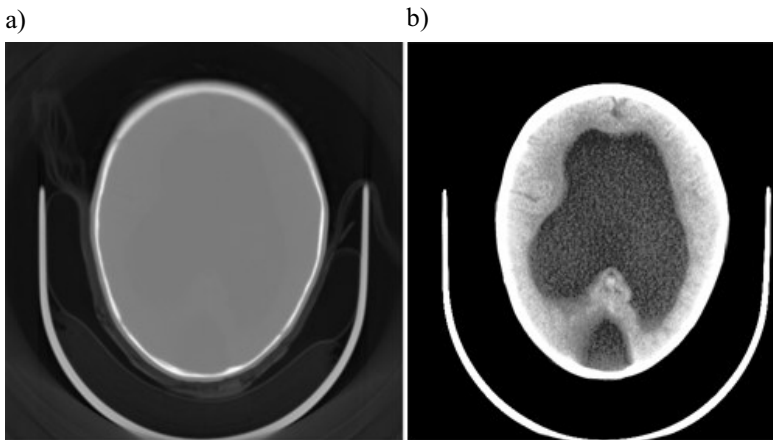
Exemplary CT image before (a), and after (b) image enhancement
